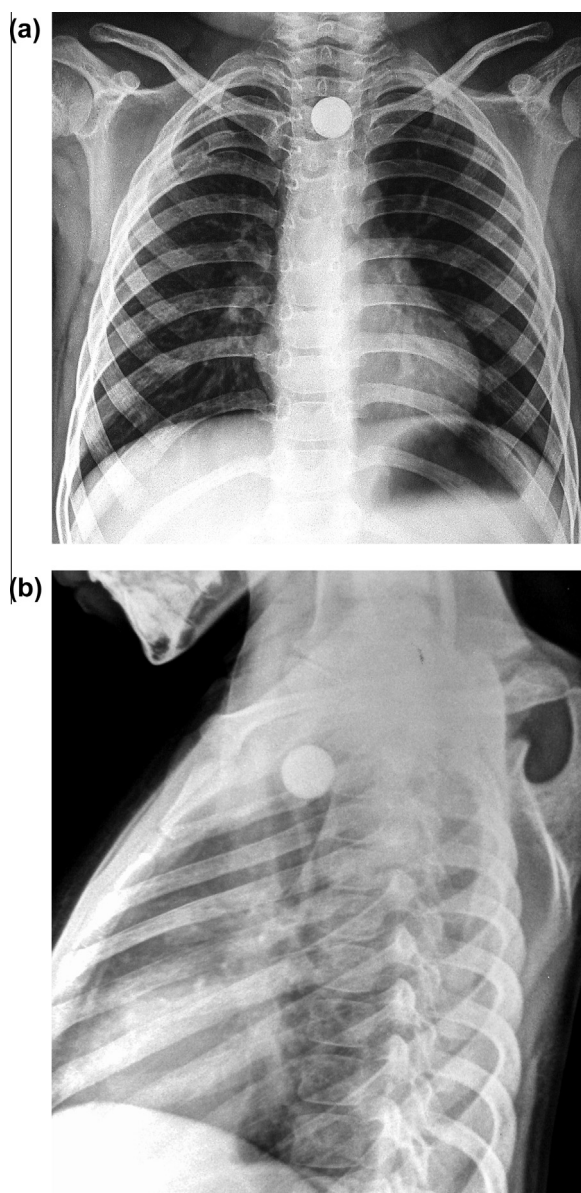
The X-ray of the neck, chest and upper abdomen ((a): antero-posterior view; (b): lateral view) shows a spherical radio-opaque foreign body lodged in the upper esophagus at the level of the second and third thoracic vertebrae.
